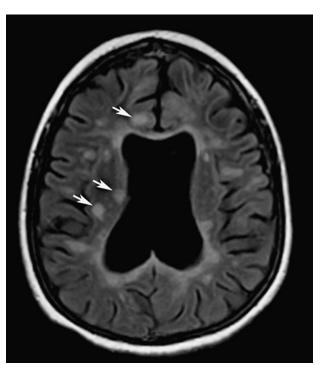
MRI FLAIR axial image revealing numerous diffuse demyelinating lesions of the periventricular white matter (arrows).
